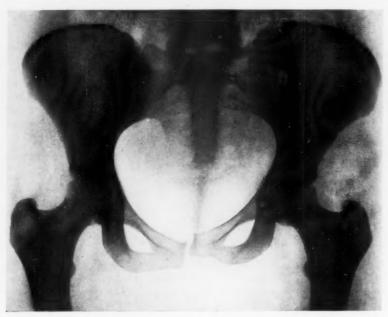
(Case 1.) Roentgenogram taken 13 months after operation, showing a filling in of the operative defect with apparently a small sequestrum present, which is not causing any trouble.
